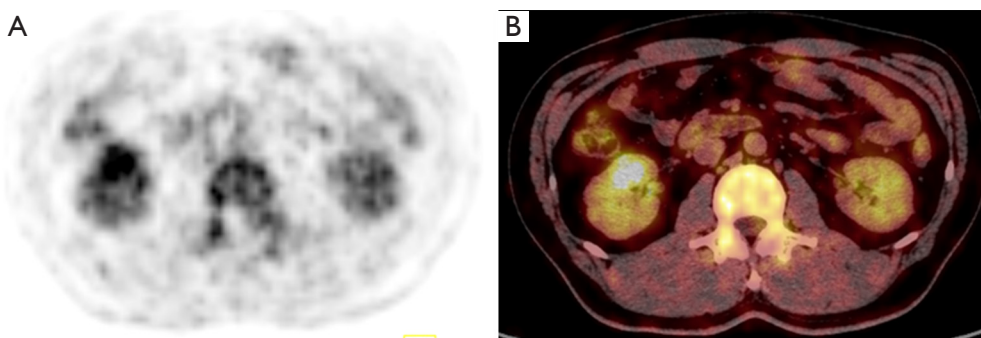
(A) ¹⁸F-FDG PET/CT image from the patient showing BSARCC positive for ¹⁸F-FDG. (B) Focal FDG radioactivity concentration in the right renal lesion with a SUVmax of 3.8; the SUVmax of the normal renal tissue around the lesion was 1.8. FDG, fluorodeoxyglucose; PET, positron emission tomography; CT, computed tomography; BSARCC, biphasic squamoid alveolar renal cell carcinoma; SUVmax, maximum standardized uptake value.
